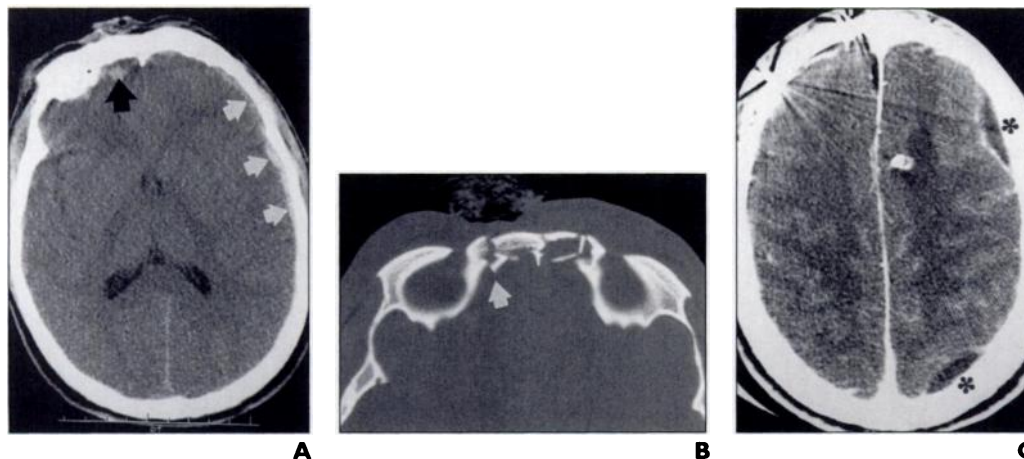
28-year-old man with head injury from motor vehicle collision. A, Unenhanced CT scan of head on day of admission shows right frontal hemorrhagic contusion (black arrow) small left frontoparietal hematoma (white arrows). B, Unenhanced axial CT scan through frontal sinus using bone algorithm and smaller field of view than in A shows depressed bone fragments (arrow) but no pneumocranium. C, Enhanced CT scan of head on hospital day 23 shows left frontal and parietal lentiform fluid collections with distinct enhancing capsules (asterisks) consistent with subdural empyemas.
